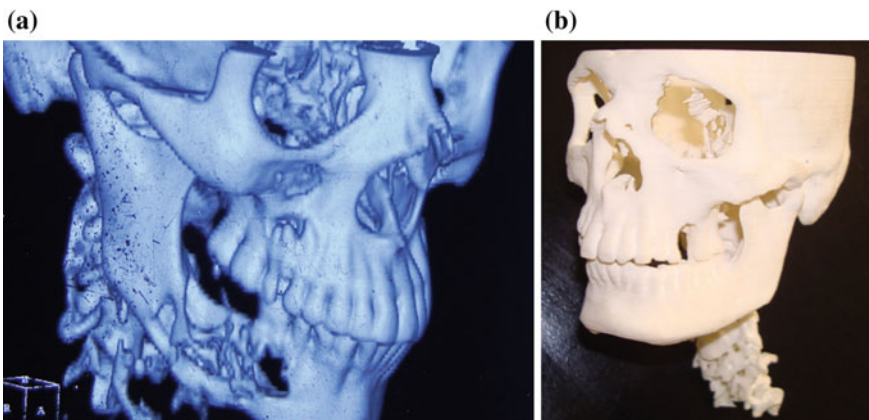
Reconstructed CT scan image, and 3D printed model made of nylon powder for teaching purpose or strategic planning
